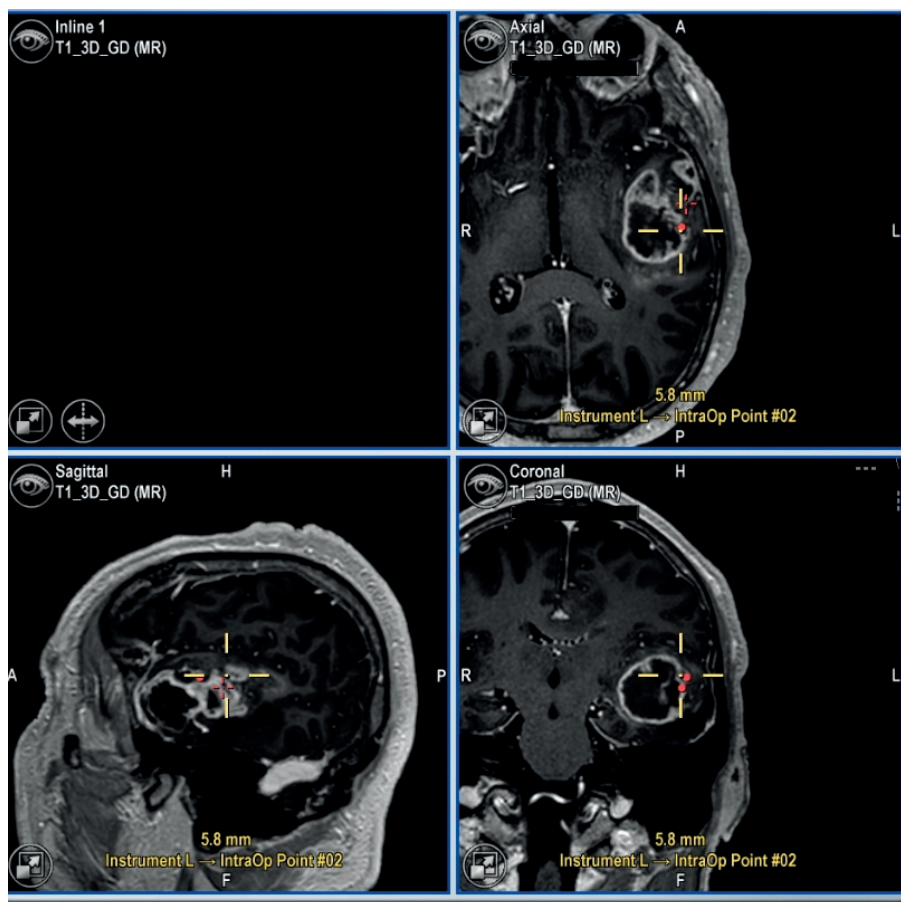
Location of tissue biopsy. The location of the biopsy was recorded by screen capture of the navigation system at the time of tissue sampling. The yellow cross shows the location of the biopsy in all planes: axial, sagittal and coronal. In this case, the biopsy was taken from the contrast-enhancing tumor. The cross-hairs on the screenshot images were then transformed into MRI coordinates.
